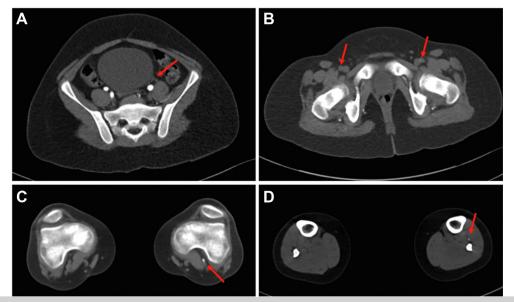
Computed tomography angiograms demonstrating complete occlusion of the left external iliac artery (EIA; A; *arrow*), bilateral occlusion of the common femoral arteries (CFAs; B; *arrows*). C, The popliteal artery in the right leg was completely occluded and minimally patent in the left leg. D, In the right leg, no filling was present in the tibioperoneal trunk, anterior tibial artery, posterior tibial artery, or peroneal artery, with no runoff branches. In the left leg, the anterior tibial artery was minimally patent; however, the tibioperoneal trunk and all other branches were occluded.
